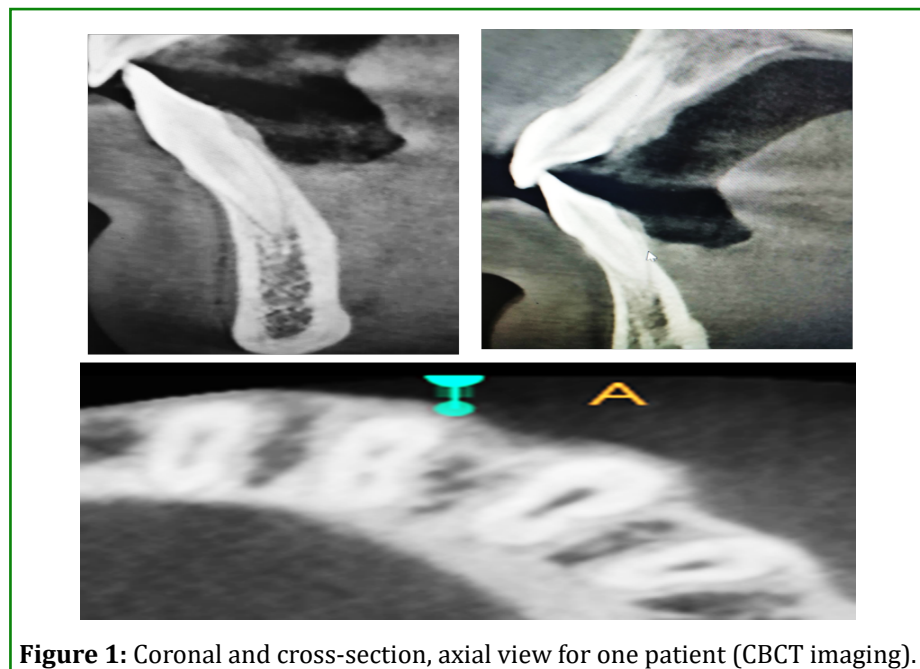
Coronal and cross-section, axial view for one patient (CBCT imaging).
